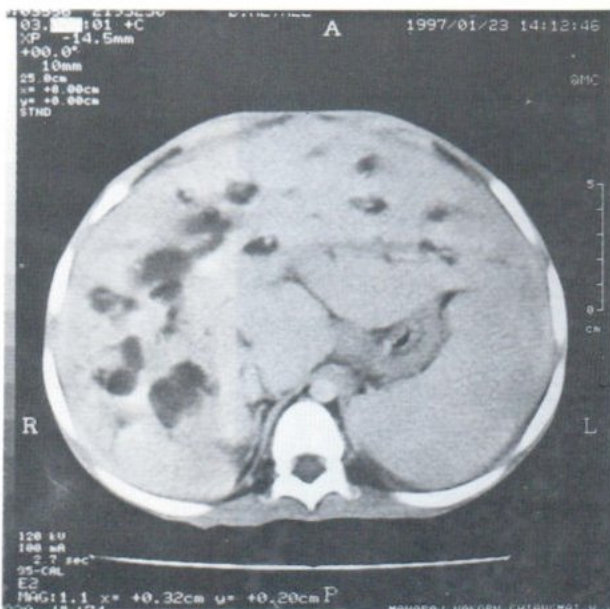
Contrast CT shows hepatosplenomegaly and saccular dilatation of the intrahepatic bile ducts.
